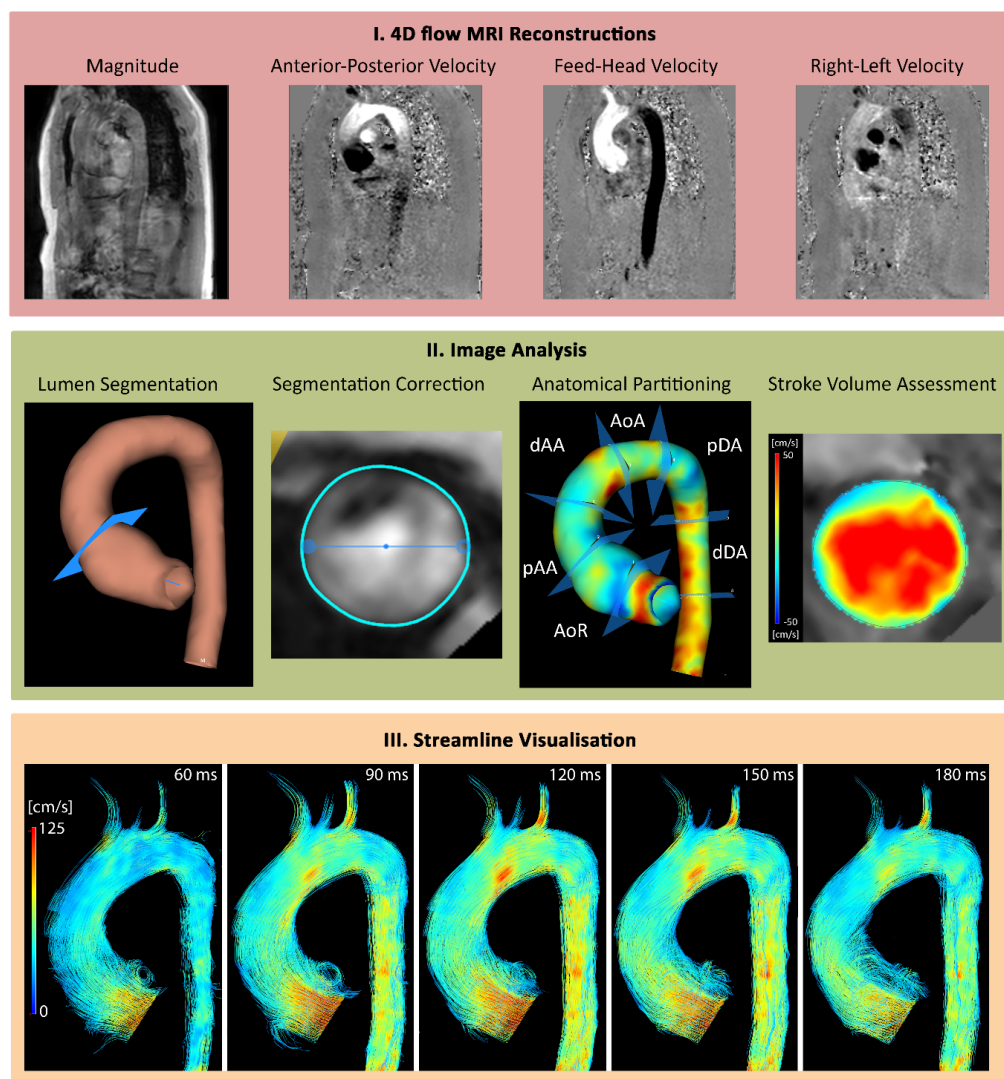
4D flow MRI visualization using CAAS MR Solutions v.5.2.1. Example of a patient (male, 45 years old) with aortic root aneurysm with a diameter of 52 mm. (I) 4D flow MRI reconstructions. (II) Image analysis including the lumen segmentation, the manual segmentation correction, anatomical partitioning visualized on the wall shear stress maps, and stroke volume assessment. (III) Streamline visualization of the 4D flow MRI at the 5 systolic phases (60, 90, 120, 150, and 180 ms). Abbreviations: AoR—*aortic root*, pAA—*proximal ascending aorta*, dAA—*distal ascending aorta*, AoA—*aortic arch*, pDA—*proximal descending aorta*, and dDA—*distal descending aorta*. Secondly, the morphology of the thoracic aortas was analyzed using an in-house developed Python software (Python Software Foundation, Wilmington, DE, USA). This tool was used to quantify aortic volume, centerline length, maximal diameter, and curvature radius of each anatomical segment and for each of the five systolic phases. The aortic diameter was determined by first constructing a cross-section perpendicular to the centerline at every millimeter. Next, at each cross-section, the maximal radial spike length was calculated. The curvature radius was derived by fitting a circle through the segments' centerline as previously described [25]. The maximal aortic diameter within each segment and the radius of the fitted circle were used for statistical analysis.
